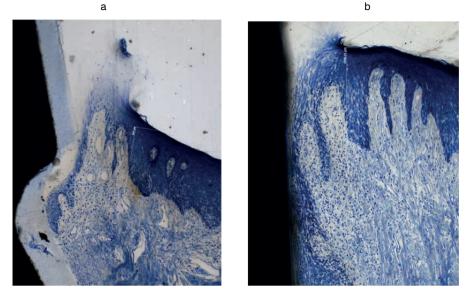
Epithelium after 15 days from implant insertion: a) Juncional Epithelium (JE) and underlying Connective Tissue (CT); b) Sulcular Epithelium (SE).
